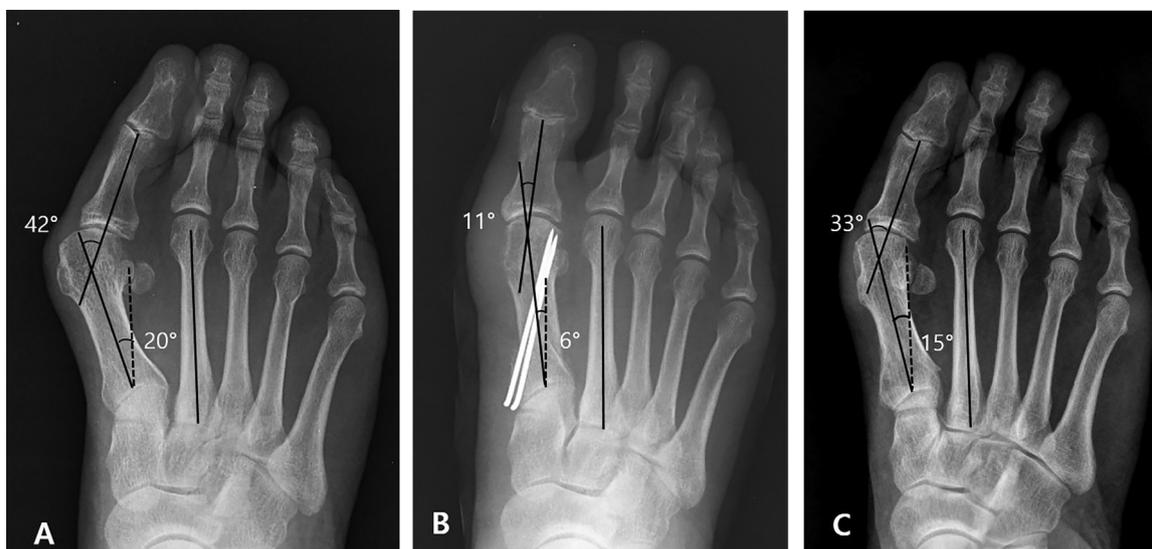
The weight-bearing radiographs of a 58-year-old woman with a severe hallux valgus deformity who underwent proximal chevron osteotomy with distal soft tissue procedure. (a) Preoperative radiograph showed 42.3° of hallux valgus angle, 20.2° of intermetatarsal angle, and grade 3 position of sesamoid. (b) Initial postoperative 6 months follow-up radiograph showed good correction such as hallux valgus angle 11.0°, intermetatarsal angle 5.8°, and grade 2 position of sesamoid. (c) Final follow-up radiograph of 72 months showed recurrence with a hallux valgus angle 33.2° and intermetatarsal angle 15.3° and non-reduction status of sesamoid.
